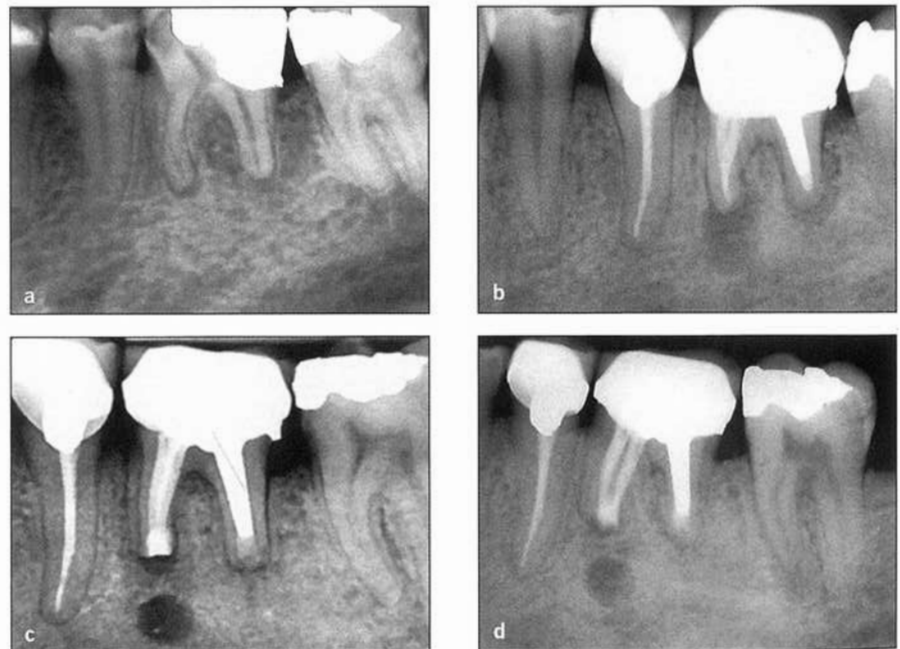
(a) Mandibular left first molar prior to root canal treatment. (b) Failure of root canal treatment 11 years posttreatment. (c) Placement of CEM cement as a root-end filling during intentional replantation. (d) Periapical healing 4 years after treatment.
